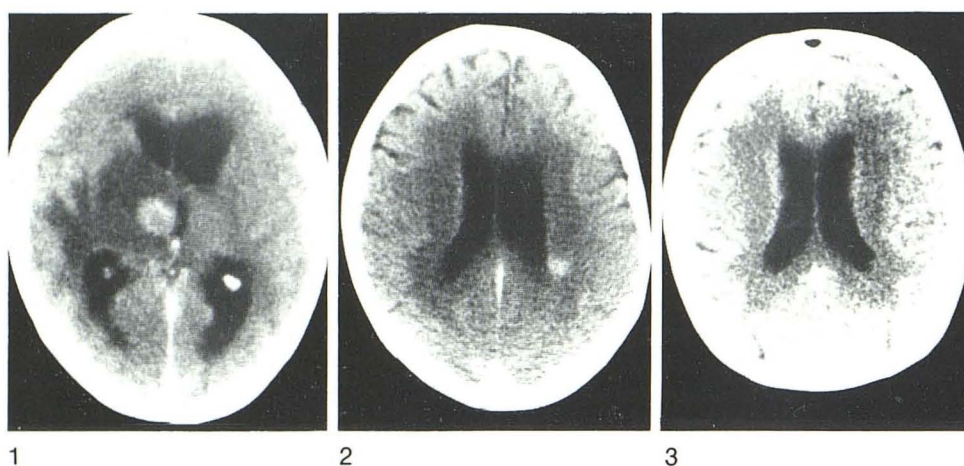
Toxoplasmosis (biopsy). CT scan with contrast enhancement. Deep, contrast-enhancing lesion with large surrounding low-density area and disproportionately slight compression of lateral and third ventricles.
